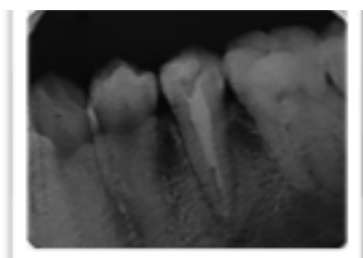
Periapical photo shows the lesion healing process of 35 after 2.5 months calcium hydroxide application
